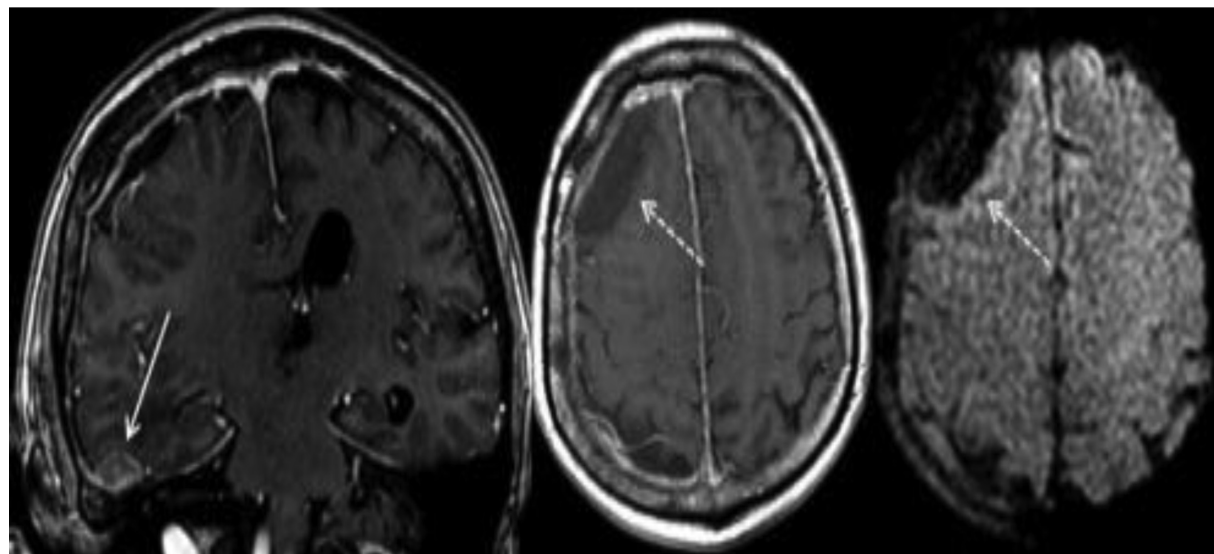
Magnetic resonance imaging scan of contrasted skull (April 2016) - weighted sequence in T1 in the coronal plane showing dural enhancement adjacent to the temporal bone. The T1 and diffusion-weighted imaging sequences in axial cuts show subdural collection without diffusion restriction.
